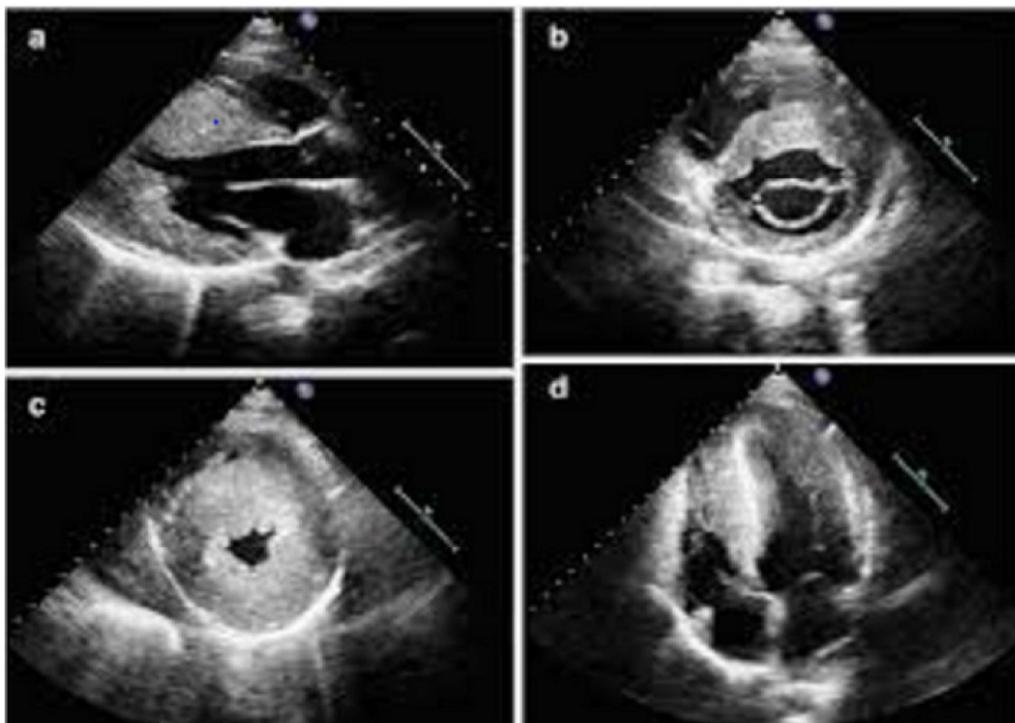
Transthoracic echocardiography showing hypertrophic cardiomyopathy
